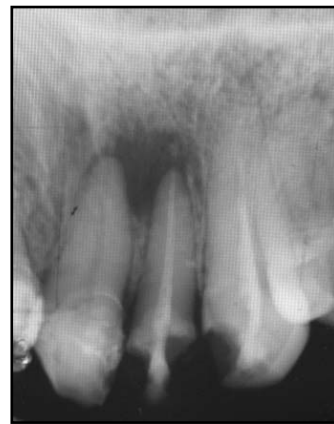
Radiographic image of 22 one month after MTA treatment
